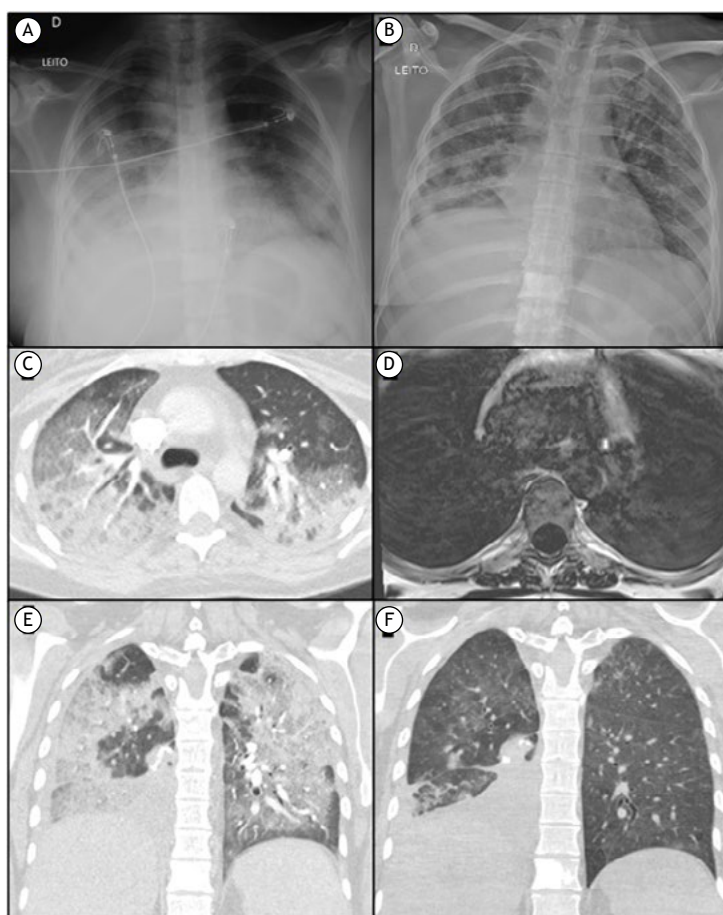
In A, bedside chest X-ray (CXR) demonstrating bilateral lung opacities in the middle and lower fields and possible right pleural effusion. In B, bedside CXR taken two weeks later showed significant improvement of lung opacities. In C, axial CT scan confirming lung involvement and extensive ground-glass opacities, sometimes tending to consolidate, along with septal thickening. In D, a spine MRI performed a few days prior to chest CT reliably ruled out previous lung diffuse abnormalities. Coronal CT scans confirmed significant improvement that were depicted in the control CXR (baseline CT scan in E vs. control CT scan taken two weeks later in F).
